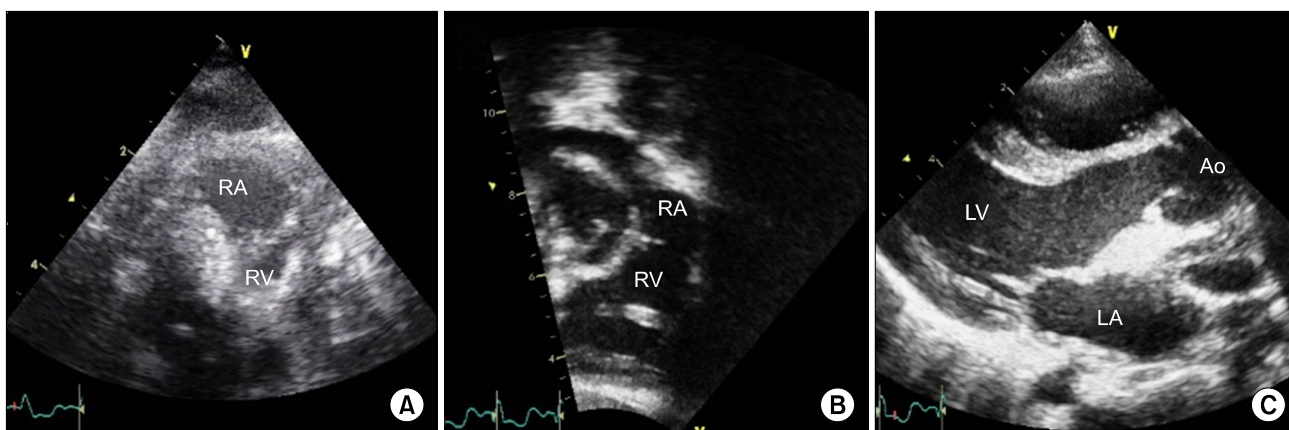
(A) Echocardiography 7 days after the operation (subcostal view) showed minimal PS and a PV size of 6.8 mm (z-score < -2.5). (B and C) Echocardiography 6 months after the operation B. Subcostal view showed mild PS and a mature PV size of 15.8 mm (z-score = +1.70) without insufficiency of the right ventricular outflow tract. (C) A parasternal long axis view showed the absence of left ventricular outflow tract obstruction. PA, pulmonary artery; RV, right ventricle; LV, left ventricle; LA, left atrium; Ao, aorta; PS, pulmonary stenosis; PV, pulmonary valve.
